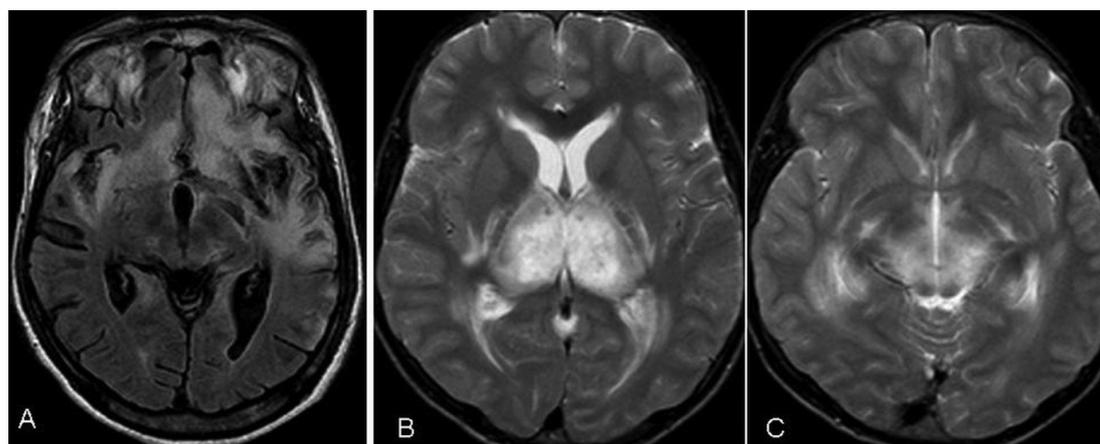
MRI (axial FLAIR sequence) showing signal changes in the bilateral temporal and orbito-frontal lobes in a patient with herpes simplex encephalitis; Figure 1B,C. MRI (axial T2W image) revealing signal changes in bilateral thalami (B), upper midbrain (C) characteristic of Japanese encephalitis
